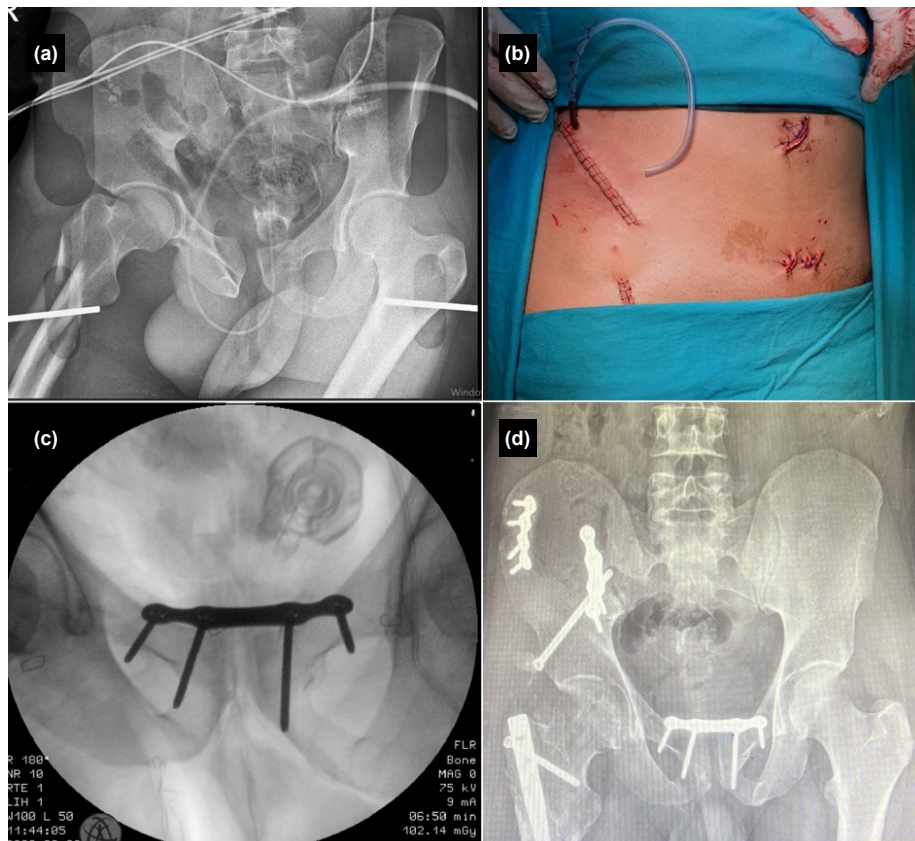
(a) Preoperative pelvis AP radiograph of a patient with an APC1 pelvic ring injury (Young-Burgess classification) and a C1-1AD injury (AO/OTA classification); (b) Incisions used during the surgery; (c) Fluoroscopic check after the surgical procedure; (d) Postoperative 22nd-month pelvis AP radiograph of the patient.
